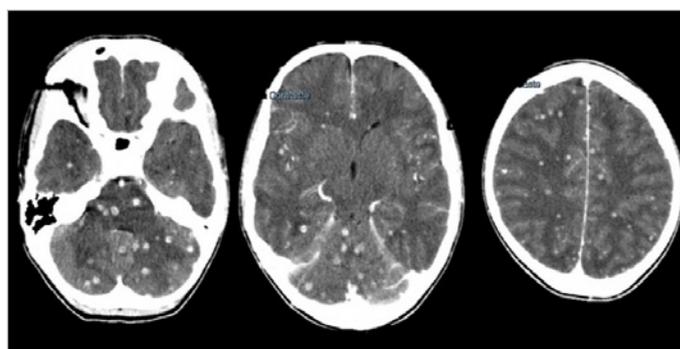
Head CT revealing multiple millimetric lesions with ring enhancement
